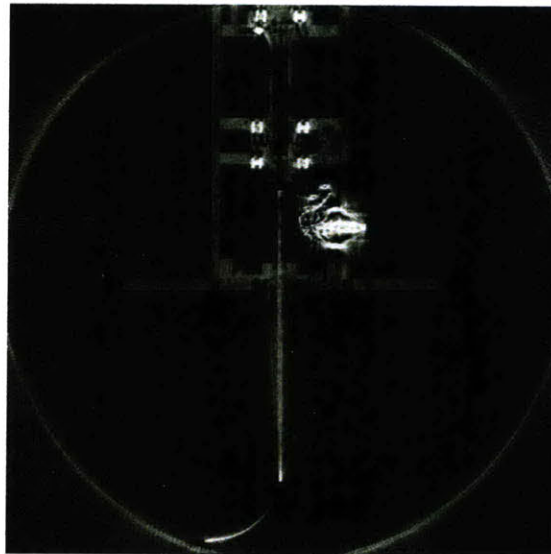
CT scan of the robot mechanism. The cannula and stylet can clearly be seen in the image and it is apparent that the motors are all out of the scan plane. The electrical connector does provide some image distortion but this could be addressed in a design revision of the device.
